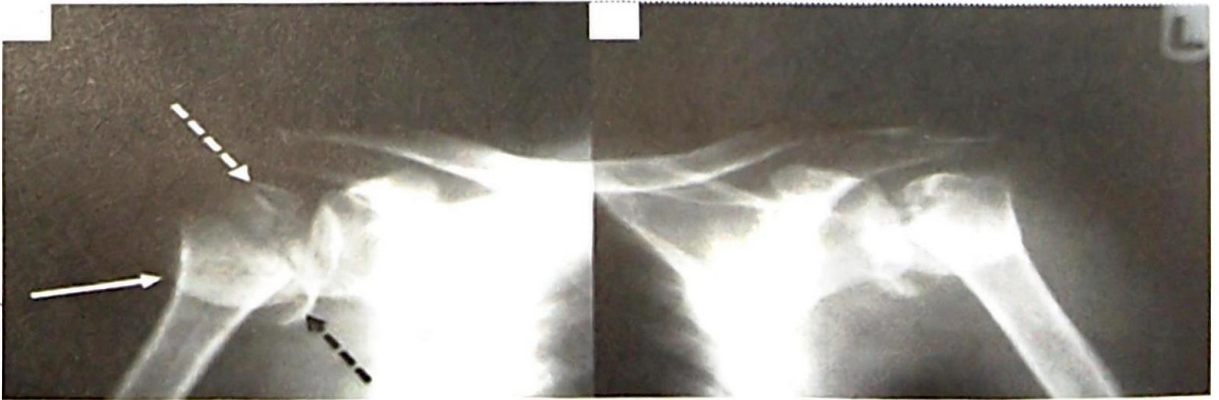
Radiographs of the shoulders showing posterior dislocations associated with four-part surgical neck fractures of the humeri bilaterally. The three small parts are labelled in figure 2a: dislocated humeral head lying posteriorly (continuous white arrow), the greater trochanter (dashed white arrow), the lesser trochanter (dashed black arrow) together with the major fragment (rest of the humerus) constitute the "4-part fracture" of the surgical neck
